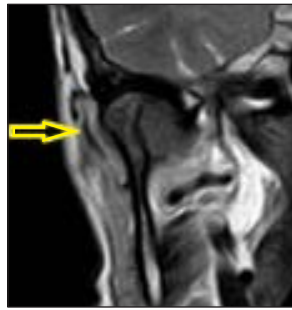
(left) MRI frontal view of the condylar mass (*arrow*) and (right) evidence of a slight lateral capsular distension (*arrow*).
